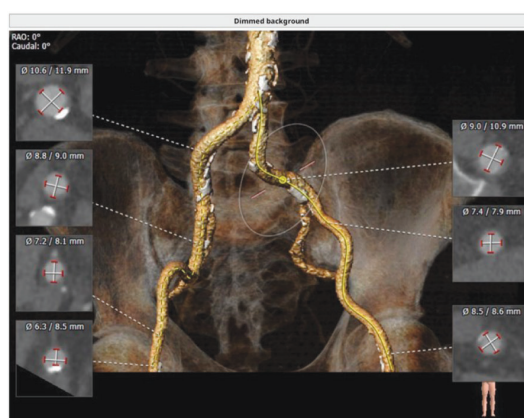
CT, iliac arteries, patient No 2
